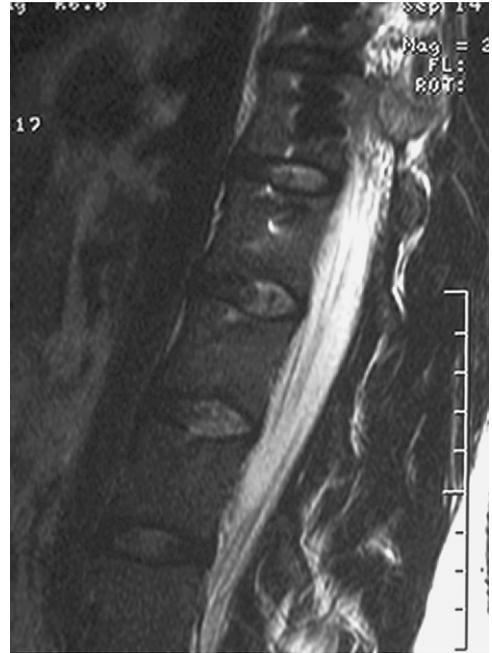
MRI of the patient in Fig. 2 showing normal-appearing well-hydrated discs.
